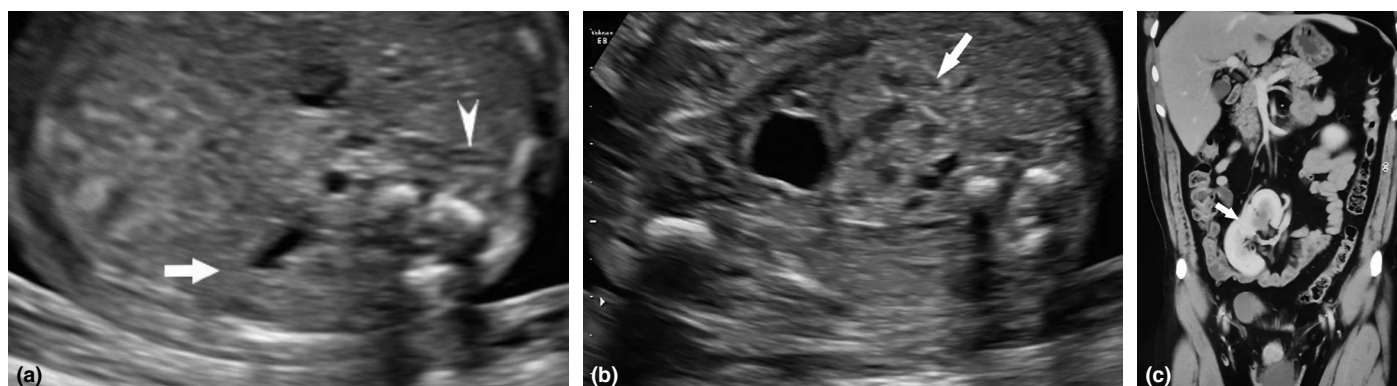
(a) Normal located kidney (arrow) and lying down sign with empty renal fossa (arrowhead) in ultrasonography. (b) Appearance of EPK in ultrasonography at the axial plane of the 22-weeks of gestation fetus (arrow). (c) Right EPK view in the coronal plane in computed tomography at 6th postnatal month (arrow).
